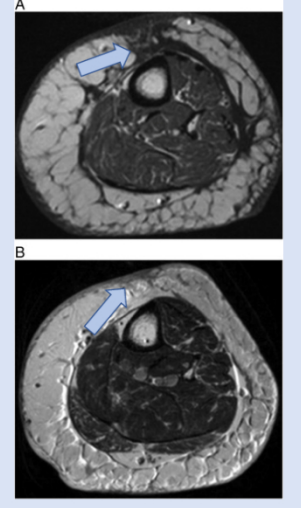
Example of T1 and T2-weighted MRI images of cutaneous angiosarcoma of the leg¹⁵
